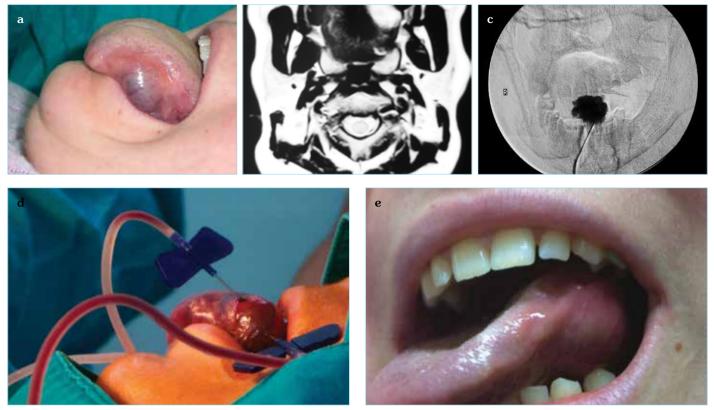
a-e. An image of a venous malformation located at the bottom left side of the tongue (a), an axial T2-weighted magnetic resonance image shows a hyperintense well-defined mass limited to the left side of the tongue (b), a direct puncture venography shows stagnation of contrast medium in the lesion (c), a view of the sclerotherapeutic session shows thrombosis of the lesion during double puncture injection. Note the change of the color of the lesion (d), complete resolution of the lesion is clearly seen (e)
